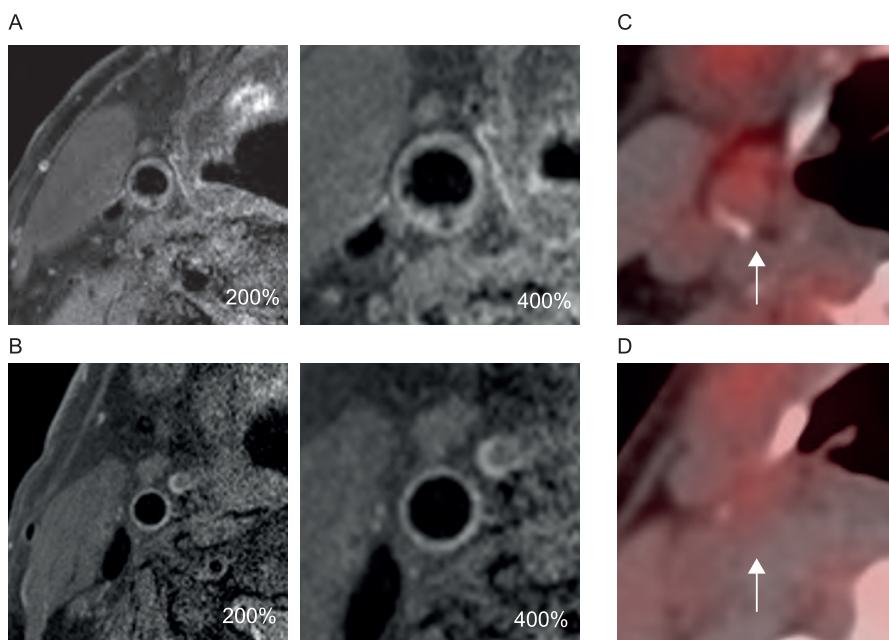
MRI and PET/CT images of the carotid artery at baseline
